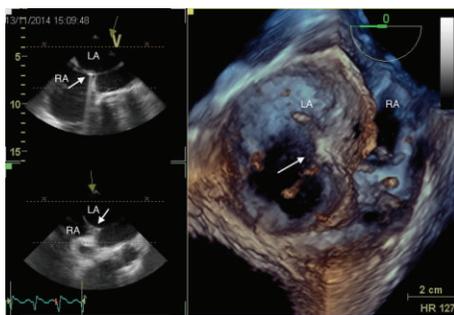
Real-time 3D echocardiography during transeptal puncture. The tip of the catheter (arrow) is passing from the right atrium (RA) to the left atrium (LA), through interatrial septum.
